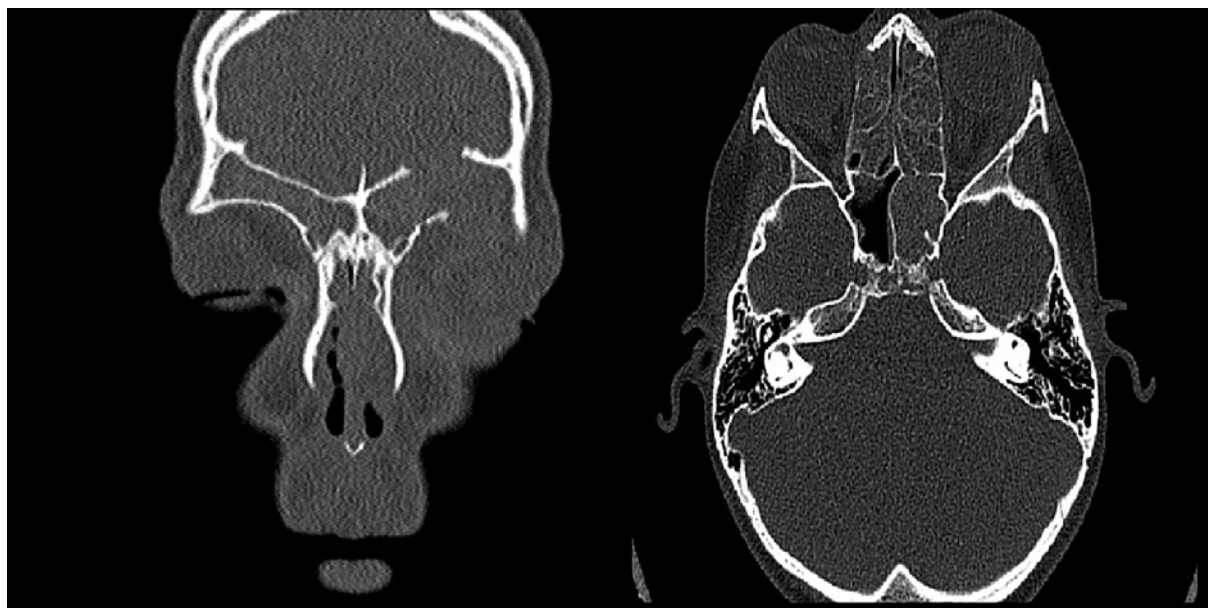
Computed tomography image of the head and orbit
